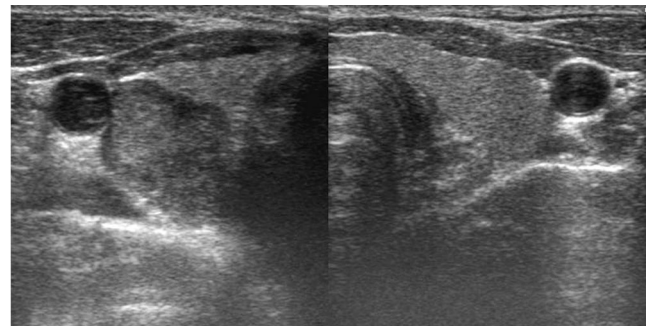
Ultrasonogram of thyroid gland shows well margined lobulating low echogenic mass in right retrothyroid area.
